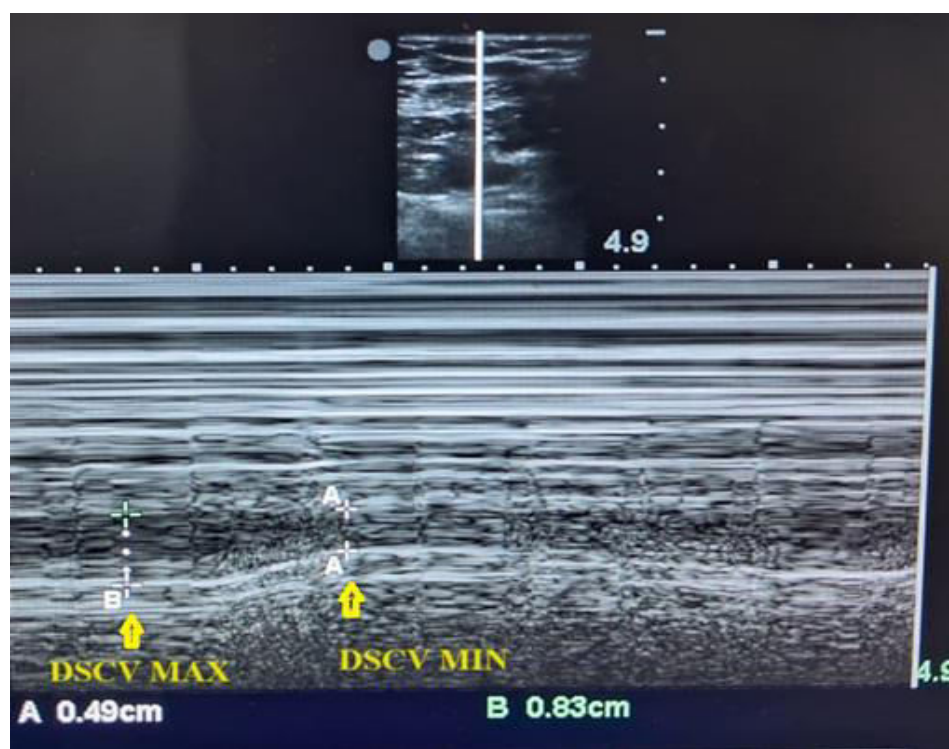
Ultrasound image showing assessment of SCV diameter
